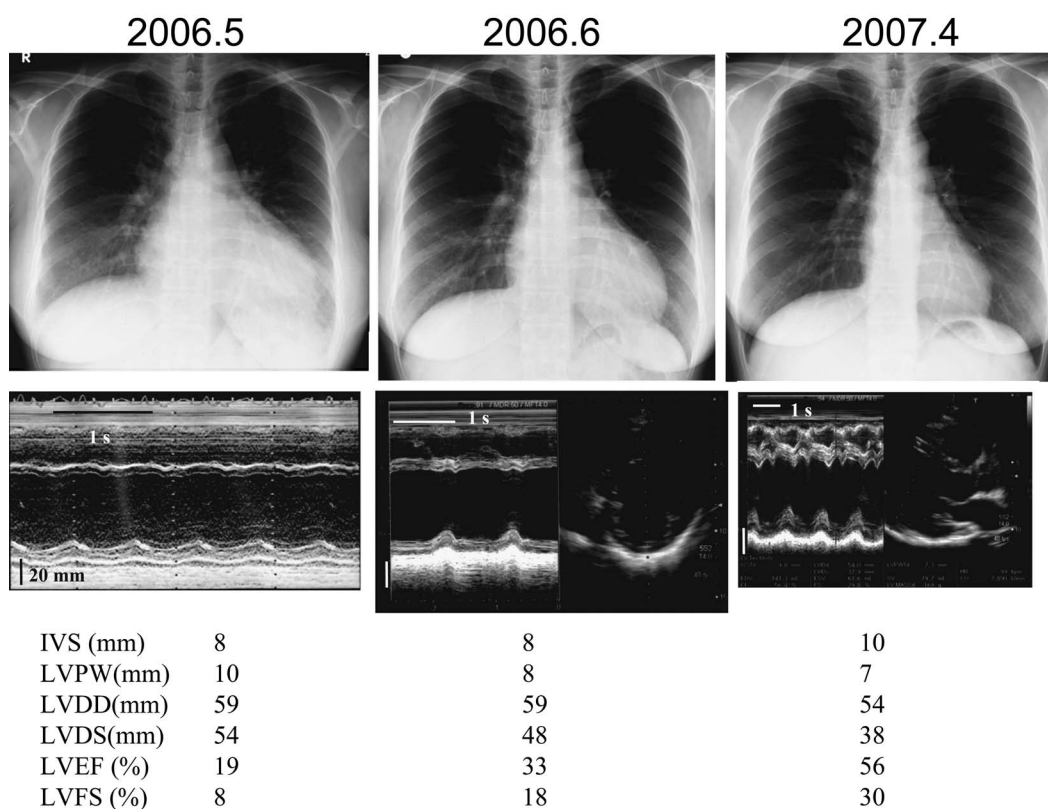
Time course of chest X-ray and echocardiography. Cardiomegaly and cardiac function gradually ameliorated.
